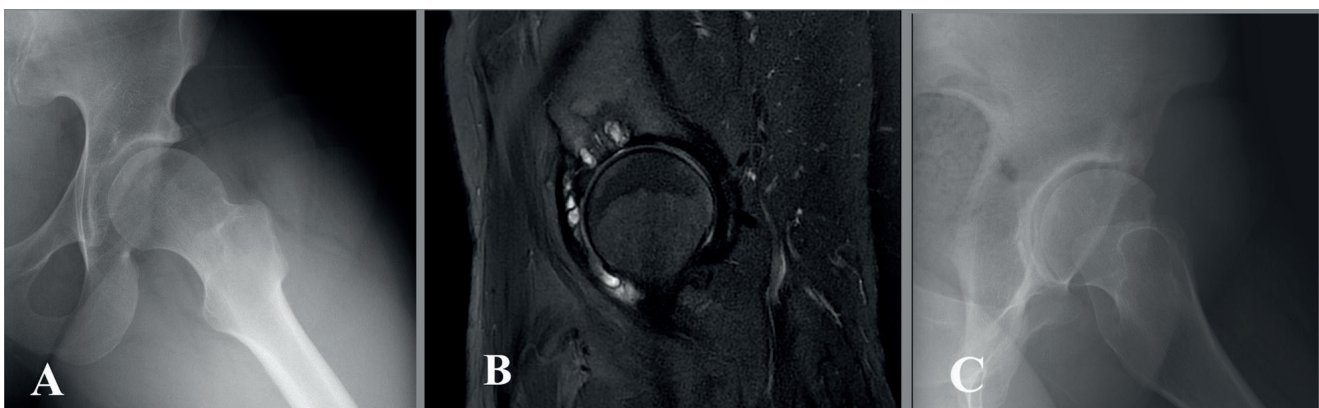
A 38 year-old female patient who underwent surgery with the AMO technique; a: pre-operative x-ray demonstrating an alpha angle of 89 degrees, b: a sagittal T2-weighted MRI section showing the degenerative para-labral cyst, and c: the post-operative x-ray demonstrating the resected cam lesion.
